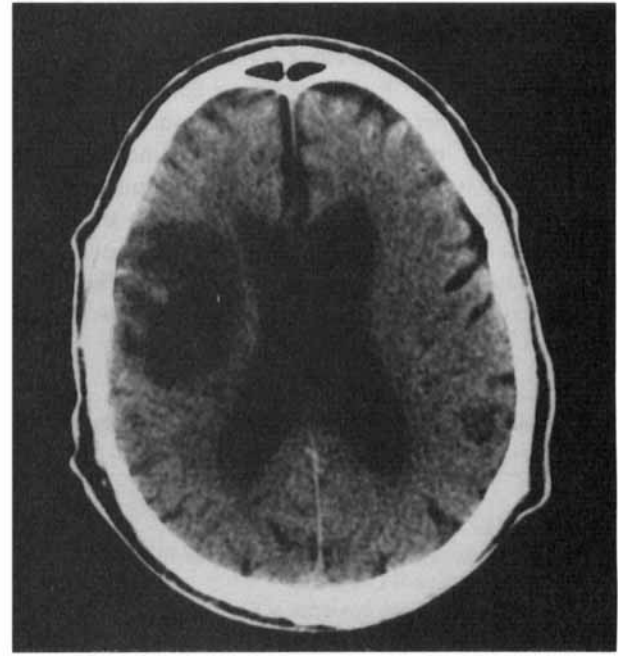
Computed tomograph of Patient 2 one week after presentation. Patient's right is viewer's left.
